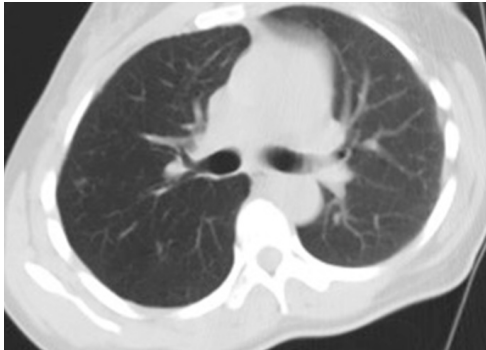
Pre-operative CT chest/thorax of a 42 year old patient with a right upper lung nodule.
